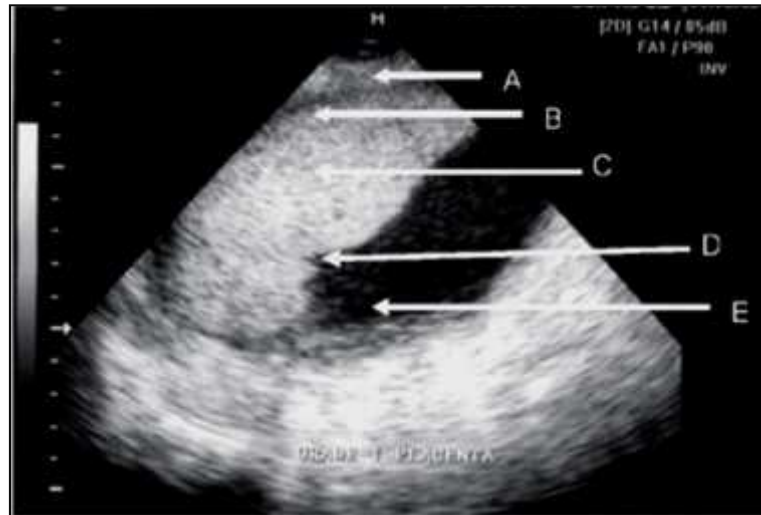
Ultrasonogram showing Grade I placenta. A= uterine wall placenta; B= basal plate; C = placental substance; D = indentation in chorionic plate; E = liquor amnii.⁽³⁷⁾
